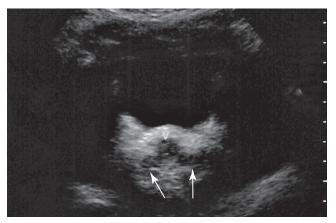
Transverse sonogram at the level of the vagina (v).
